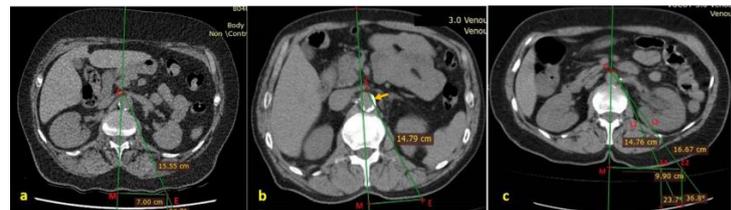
Axial thin section noncontrast abdomino-pelvic CT images at L1 vertebra level; a. Needle entry point (E1) is 7 cm left from the midline (M) in accordance with the classical transaortic celiac plexus block technique. A line was drawn between E and the celiac plexus (C), passing through the aorta. The angle between this line and the vertical line passing through the middle of the spinous process was recorded as the needle entry angle. b. Yellow arrow points extensive aortic mural calcification. c. Needle entry point in classical transaortic (CPB) technique, the main line is not passing through the aorta (L1). When a new line (L2) is drawn from the celiac plexus oppositely which is passing through the abdominal aorta, the new (optimal) needle entry point is located at a point farther from the midline (7 cm vs. 9.9 cm). The needle entry angle is 23.7° for L1, while it is 36.8° for L2. The distance from entry point to needle tip (C) is 14.76 cm for L1 and it is found as 16.67 cm for L2. This trace is penetrating the left kidney as a complication. (M= Midline, C= Celiac plexus, E1= Entry point 1, E2= Entry point 2, L1= Line 1, L2: Line 2)
